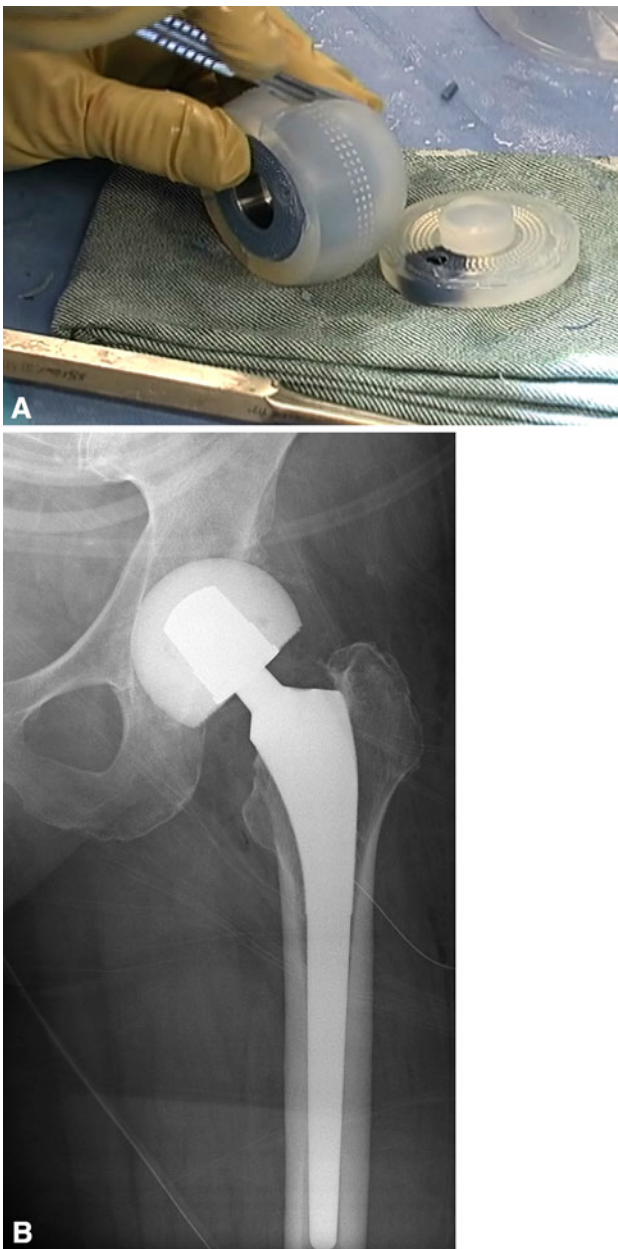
B (A) More recently, disposable molds adaptable for partial radical débridement (StageOne Select; Biomet, Warsaw, IN, USA) have become available to fabricate the articulating antibiotic-laden cement spacer. (B) Radiograph reveals an interim articulating cement spacer fabricated with a disposable mold.
